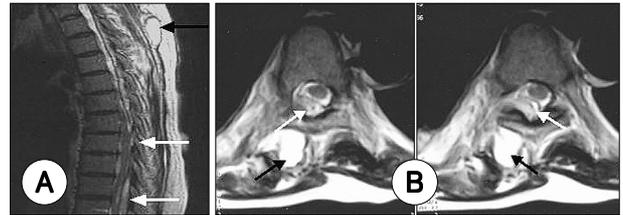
A : Preoperative sagittal T2-weighted magnetic resonance image shows, high signal intensity masses in the epidural space from T6 to T11 level (white arrows) and in the subcutaneous tissue at the level of T3/T4 where the epidural catheter was inserted (black arrow), B : Preoperative enhanced axial T1-weighted magnetic resonance images show a slightly enhanced mass (white arrow) compressing the dura in the posterior space and mass in the subcutaneous tissue (black arrow).
